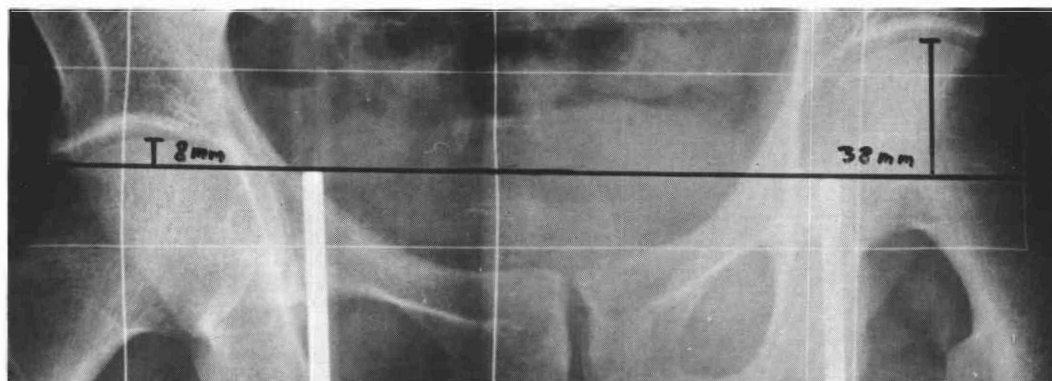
A radiograph taken for measurement of the length of lower limb prosthesis. In this case there is 30 mm shortening of the prosthetic limb (right).
